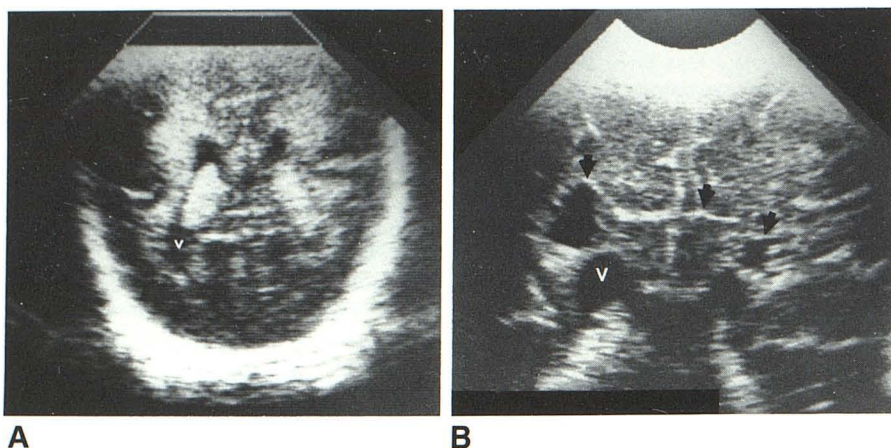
PVL. Early CT not performed. Hemorrhagic and nonhemorrhagic variant not distinguished. A, Early sonogram at 2 weeks of age shows periventricular echogenic halo. B, Follow-up sonogram 3 weeks later shows bilateral cysts in corona radiata (arrows). v = ventricle.
